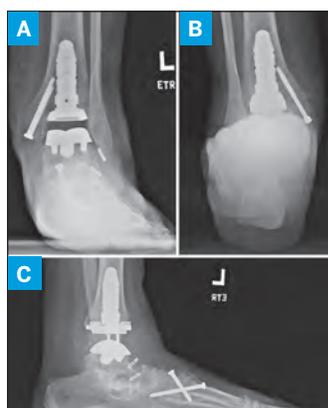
Postoperative AP (A), hindfoot (B), and lateral (C) radiographs demonstrate total ankle replacement, ankle deformity correction, and neutral hindfoot alignment.
